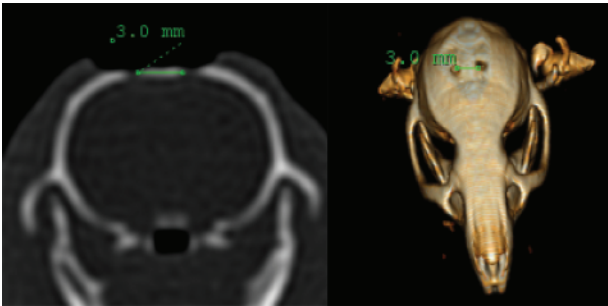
Distance measurement on computed tomography images.
